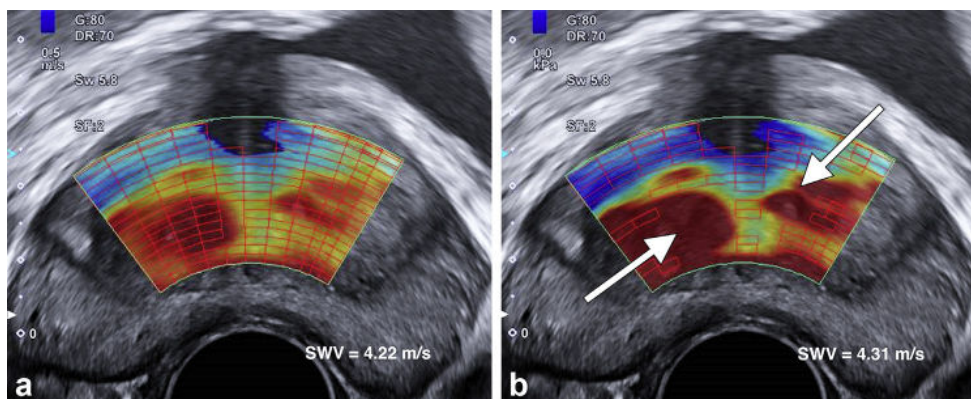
Baseline ultrasound elastography imaging from the same patient, in slightly different axial slice across the middle third of the gland. Observe the placement of a large elastographic map, including the transitional zone of both prostatic lobes simultaneously in (a) and (b). In (b), multiple areas of loss of elastographic measurement are observed (nonchecked areas, arrows). SWV data were, therefore, obtained from the map shown in (a). SWV = shear wave velocity.
